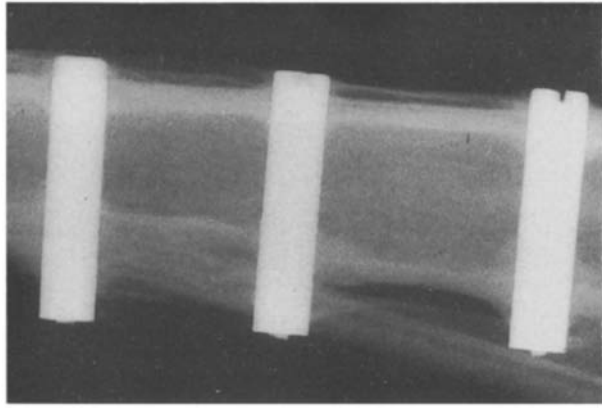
Radiograph taken four months after implantation of the tibia implants.
